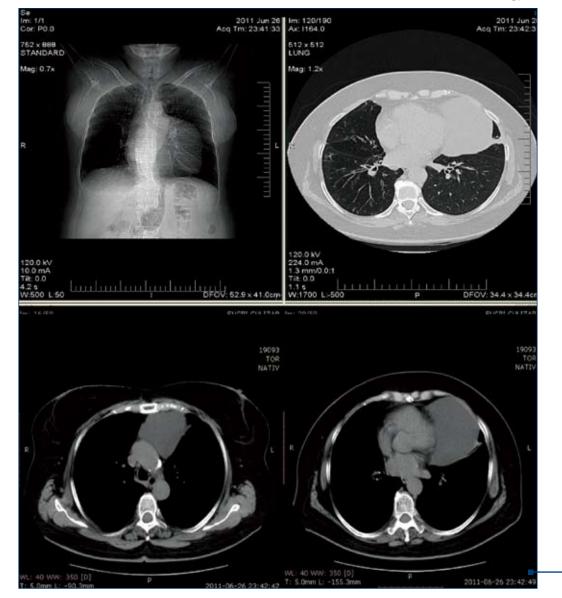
CT scan of the chest performed in 26th of July, 2011 reveals an effusion localized in the left pleural space, left lower lobe bronchiectasis and fibronodular lesions in the apical segment of the right upper lobe
